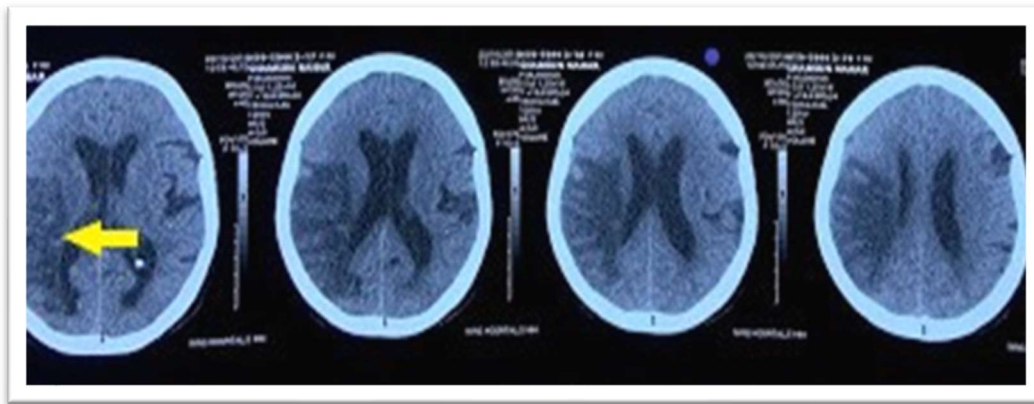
Sequential CT images showing right MCA territory defect
